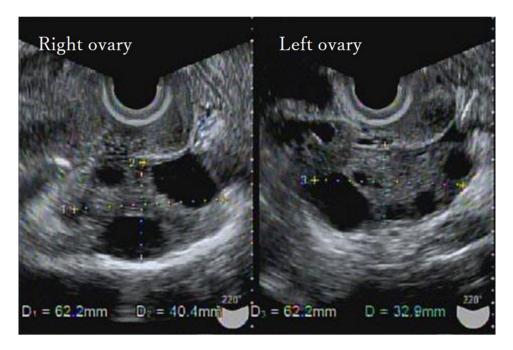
Six months after the surgery, transvaginal ultrasound showed that the long diameter of both ovaries had shrunk to approximately 6 cm
